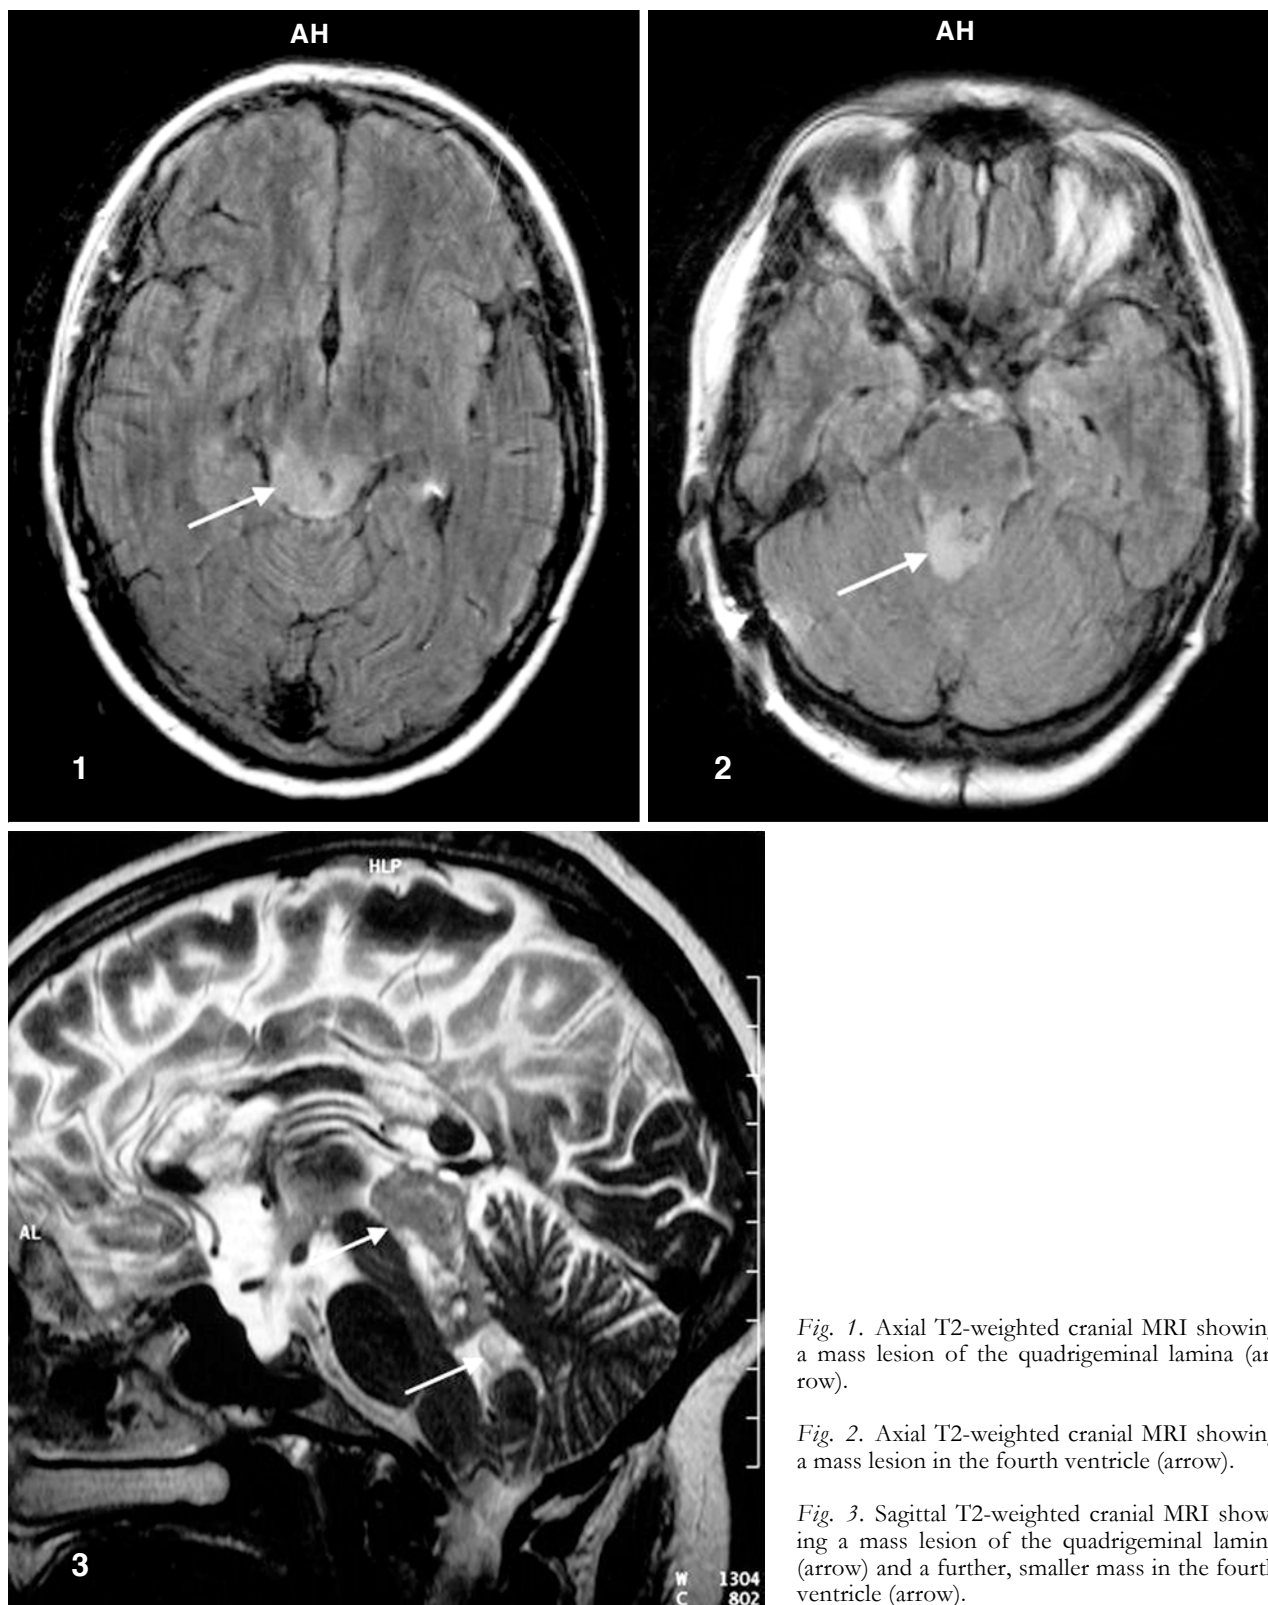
Axial T2-weighted cranial MRI showing a mass lesion of the quadrigeminal lamina (arrow).
